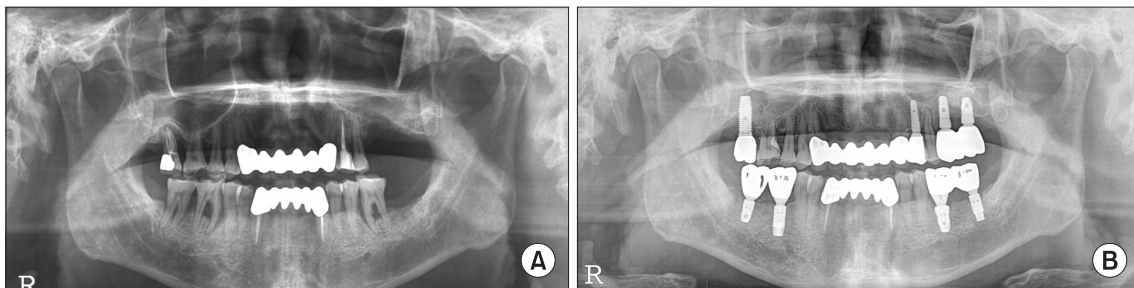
Change in alveolar bone height (Case 3). A. Preoperative panoramic radiograph. B. Panoramic radiograph 53 months after sinus-bone graft: The failed implant was removed and replaced with a wide and long implant.
